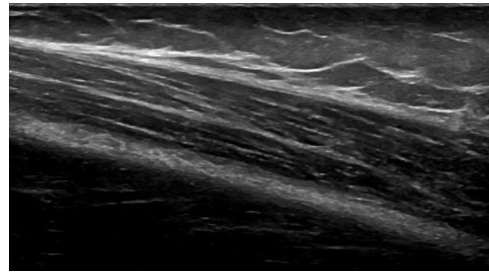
Example of ultrasound imaging (one snapshot of triceps muscle), which shows fat and subcutaneous tissue layer above the upper aponeurosis.
